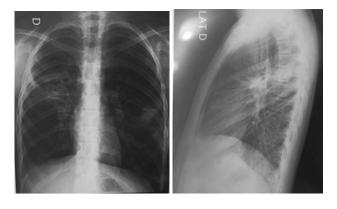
Chest X-ray in 2 projections taken 1 year after surgery.
